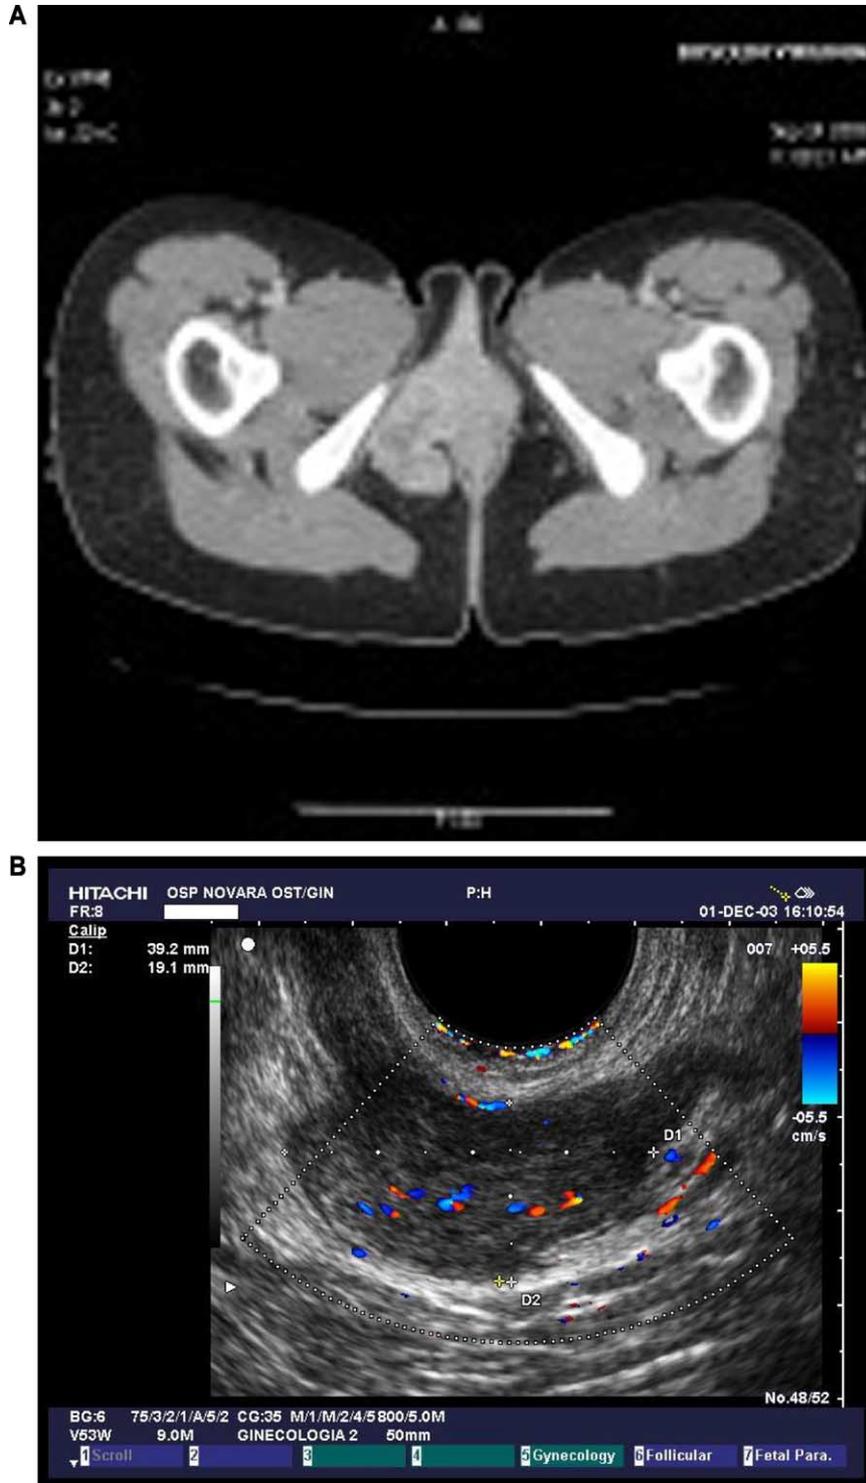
CT of the pelvis (A) revealed the presence of a solid formation characterised by uneven late contrast enhancement on the right, in the adipose tissue between the internal obturator and levator muscles of the anus. Transperineal echography (B) revealed an ovoid mass with a homogeneous echotexture and poorly defined margins; colour-Doppler demonstrated irregular, thin and randomly dispersed vessels in the central area of the tumour.
